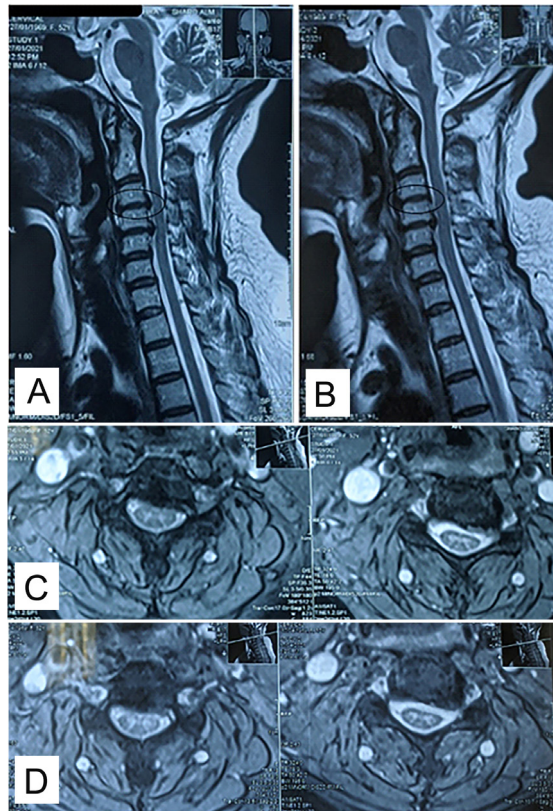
(A) Sagittal MRI cervical spine before the procedure and (B) MRI done 3 months after intradiscal ozone injection showing decrease in disc size (disc level 3-4), (C) MRI cervical spine axial view before the procedure and (D) MRI cervical spine axial view 3 months after intradiscal ozone injection.
